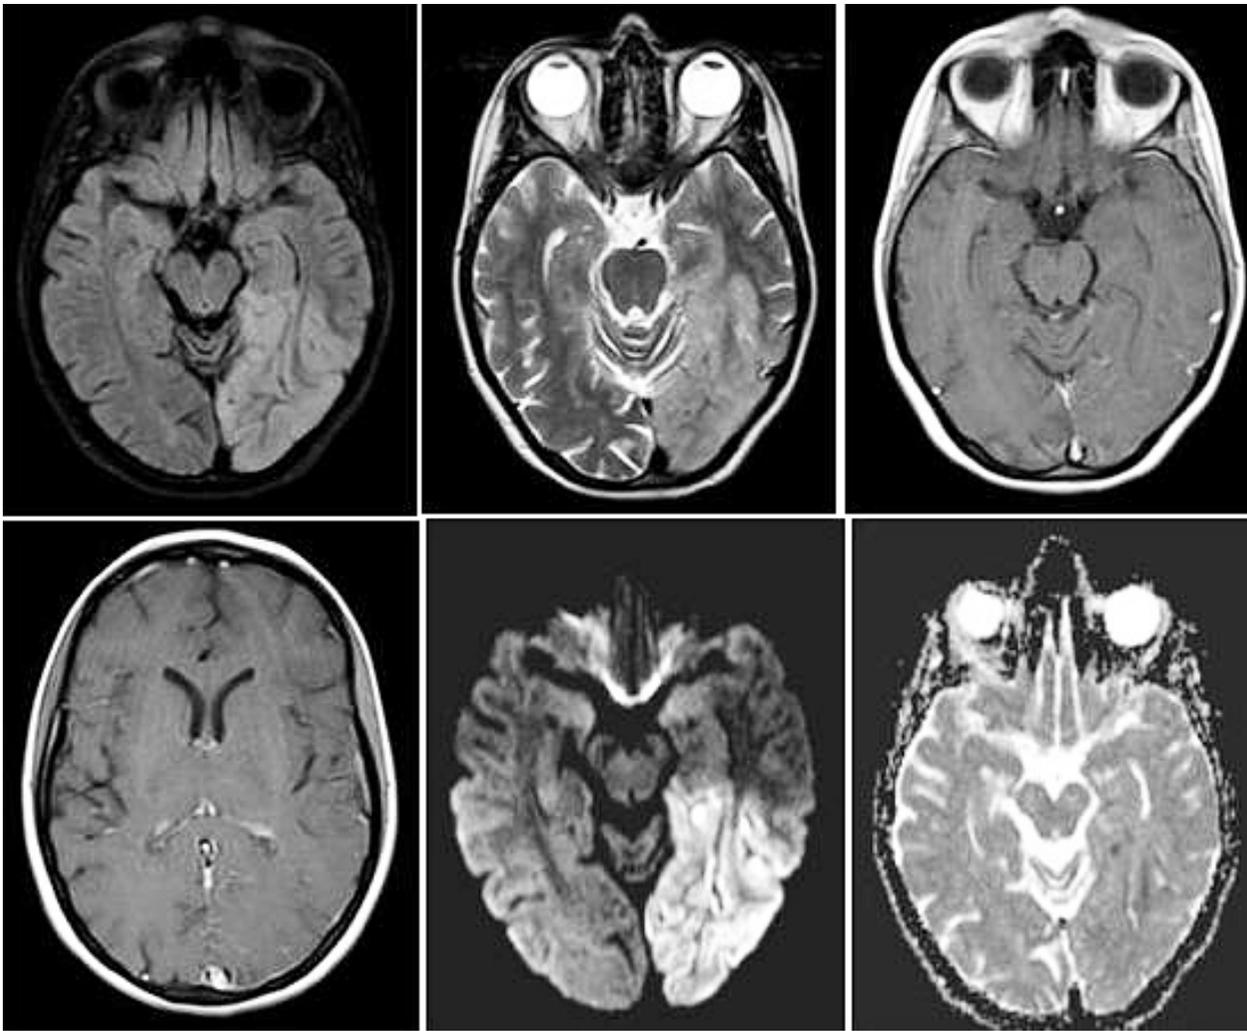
Cranial MRI on the first day: Hyperintense images on the left parahippocampal gyrus, and effacement of the left occipitotemporal sulcus (top left: FLAIR; right: T2 –weighted images). Absence of restricted diffusion (bottom left), lack of contrast enhancement on post-contrast images (bottom right).
